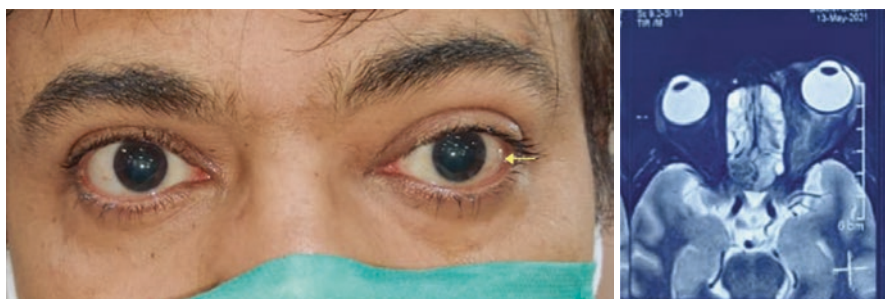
Left-sided conjunctival congestion with mild proptosis noted in a patient post-COVID-19. MRI image showing diffuse orbital involvement of the left side suggestive of orbital mucormycosis
